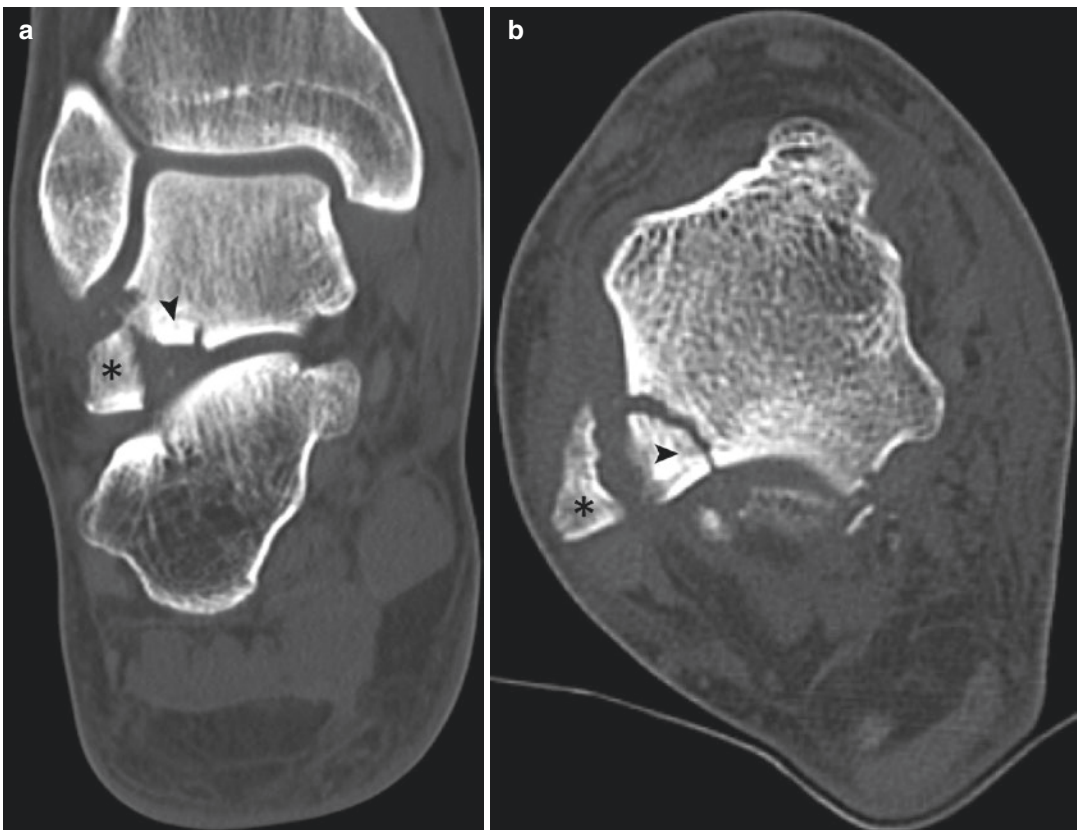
Coronal (a) and Axial (b) plane CT images demonstrate a large lateral process fracture (*) with posterior facet impaction (▶)
